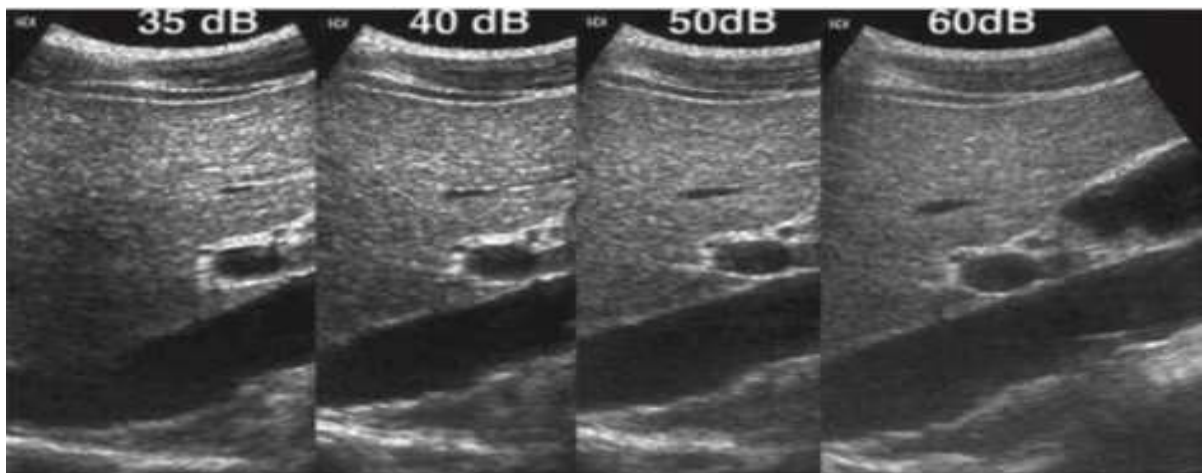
11-3 Dynamic range. The ultrasound receiver must compress a wide range of amplitudes returned to the transducer into a range that can be displayed to the user. Here, data compression and remapping are demonstrated to display dynamic ranges of 35, 40, 50, and 60 dB. The wider dynamic range offered (60 dB) allows for the best discrimination of subtle differences in echo intensity and is preferred for most imaging applications. Narrower ranges increase the clarity of larger echo difference. Displaying Images Ultrasound signals can be displayed in several ways. Over the years, imaging has evolved from simple Mode A (amplitude mode) and stabilized display to high-resolution, real-time, grayscale. imaging. Older Mode A devices displayed the voltage generated across the transducer by a backscattered echo as a vertical line on the face of the oscilloscope. Horizontal time scanning of the oscilloscope to indicate the distance from the transducer to the bound surface. In this form of display, the strength or amplitude of the sound is indicated by the vertical pumping height displayed on the oscilloscope. Using ultrasound in mode A, the position and strength of the structure are recorded. Echo-only Another simple form of imaging, M-mode ultrasound, displays the amplitude of the echo and shows the position of the moving equalizers (Figure 3-12). M-mode imaging uses the brightness of the screen to indicate the intensity of the associated signal[28].
